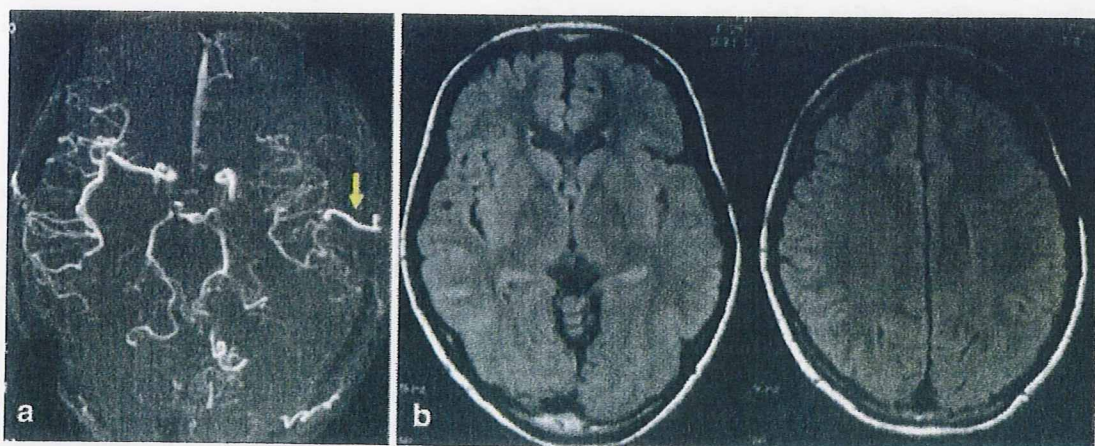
Preoperative MRA (a), FLAIR of MRI (b), and <sup>123</sup>I-IMP-SPECT at rest (c); steno-occlusive changes at the terminal portion of the internal carotid artery were evident bilaterally (a). FLAIR
